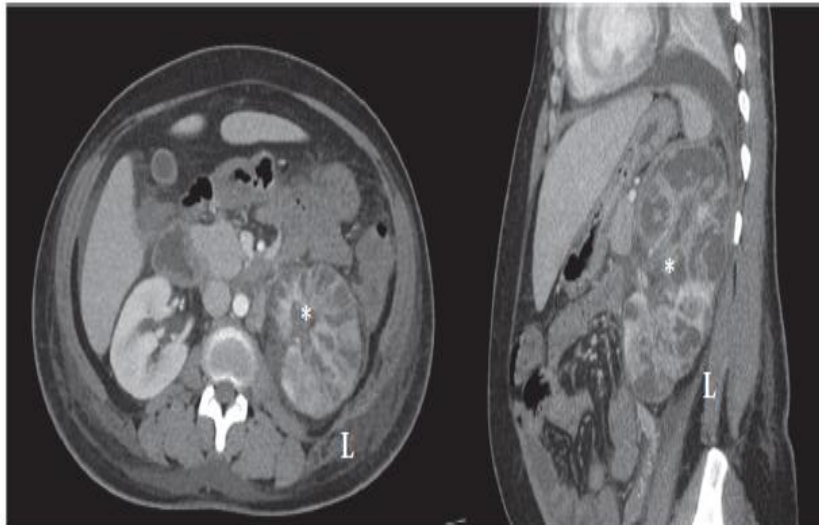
CT of abdomen, axial and sagittal views, with findings of multifocal areas of parenchymal infection and necrosis to left kidney*
